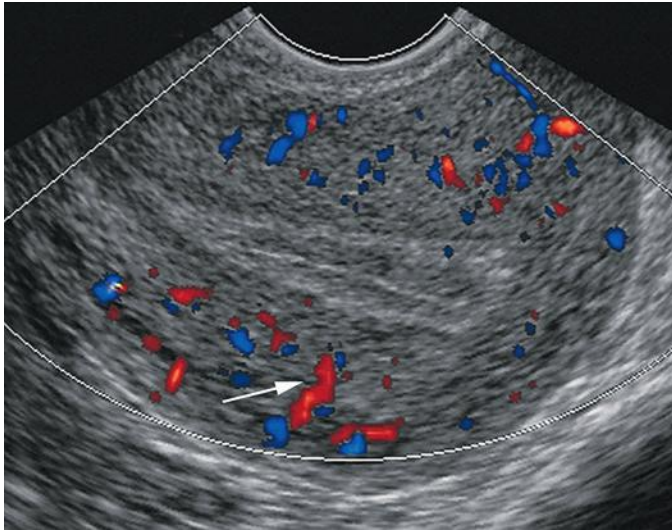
Uterine radial artery. Transvaginal color Doppler sagittal image in a patient with a retroverted uterus. A radial artery (*arrow*) is demonstrated coursing perpendicularly from the arcuate arterial plexus toward the endometrium. The thickness and trilaminar appearance of the endometrium indicate that the patient is in the periovulatory stage of the menstrual cycle.
